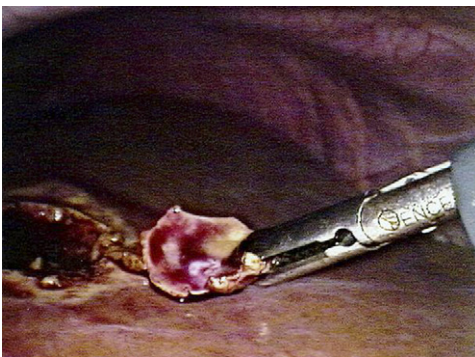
Laparoscopic wedge biopsy of a CT-occult liver metastasis identified with laparoscopy.
